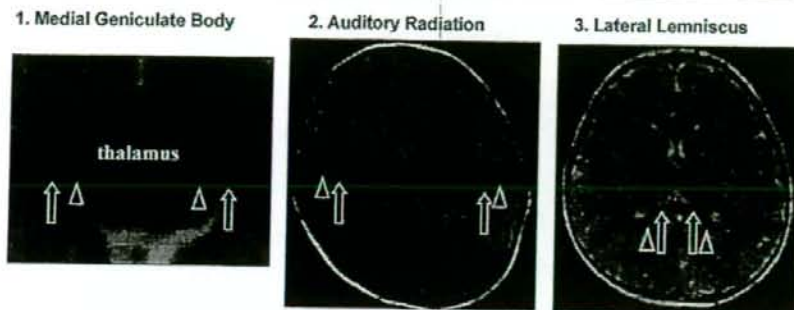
Depiction of ROIs (T2-weighted images). Arrow indicates each point of the central auditory pathway (medial geniculate body, auditory radiation and splenium of the corpus callosum), with arrowhead indicating the surrounding gray or white matter. The identification of the structure was confirmed by consulting a fetal neuroanatomy textbook along with data from a previous study on term neonates. (1) Medial geniculate body (arrow) and surrounding white matter (arrowhead). (2) Auditory radiation (arrow) and surrounding gray matter (arrowhead). (3) Splenium of the corpus callosum (arrow) and surrounding gray matter (arrowhead). After pointing these structures we did region-of-interest (ROI)-based analysis using Centricity Web-J software (GE Yokogawa Medical System Co. Ltd., Tachikawa, Japan).
